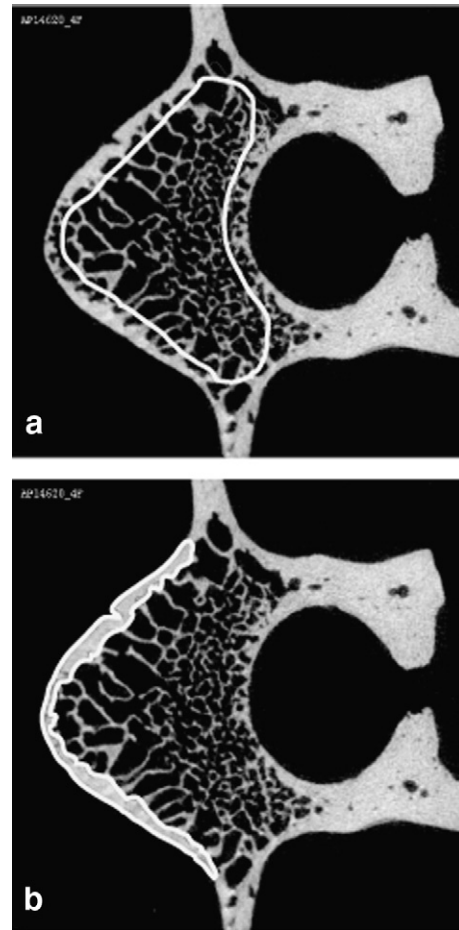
Micro-computed tomography grayscale images showing the L5 vertebral body. The trabecular bone volume of interest (a) approached the endosteal boundaries of the vertebral body. The cortical bone volume of interest (b) encompassed the ventral cortical shell.
